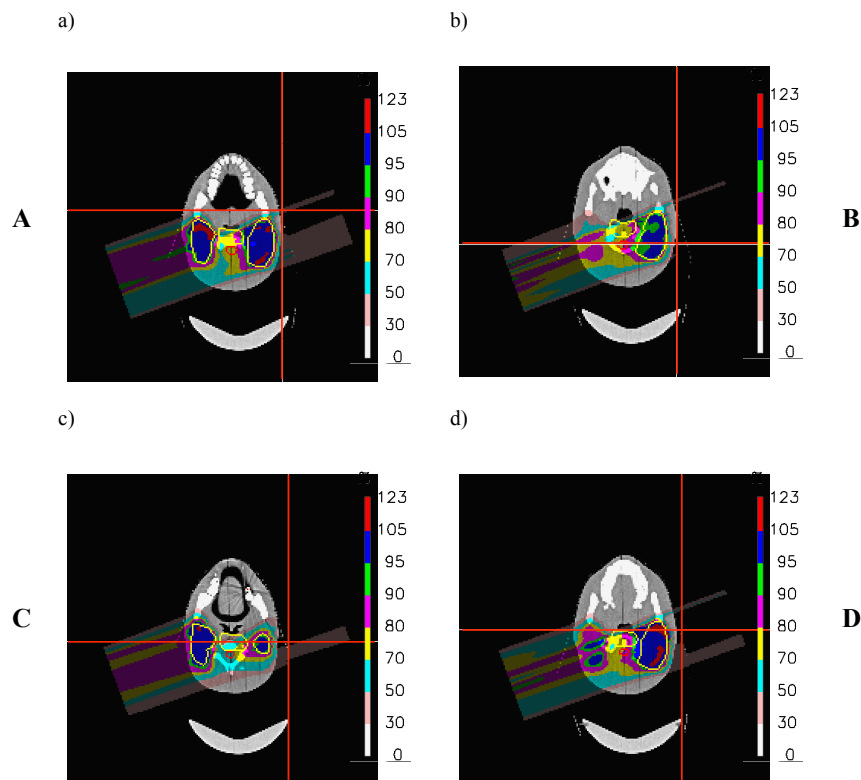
Representation of the detector positions in the nominal scenario and dose distribution obtained using the robustness plan. a) Point A; 1st point in the direction of the field. CT coordinates: 158, 148, 111. b) Point B; 2nd point in the direction of the field. CT coordinates: 159, 121, 104. c) Point C; point with the greatest dose difference between the nominal and the overshooting plan. CT coordinates: 162, 130, 117. d) Point D; point with almost no dose in the nominal plan. CT coordinates: 162, 137, 107.
